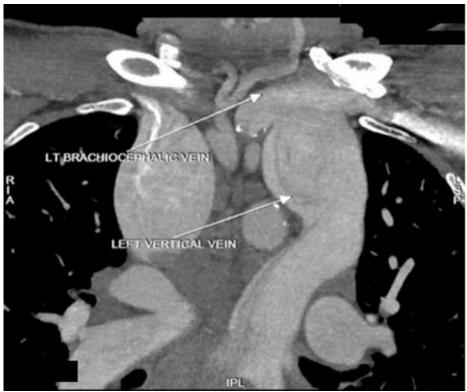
Coronal cardiac CT
